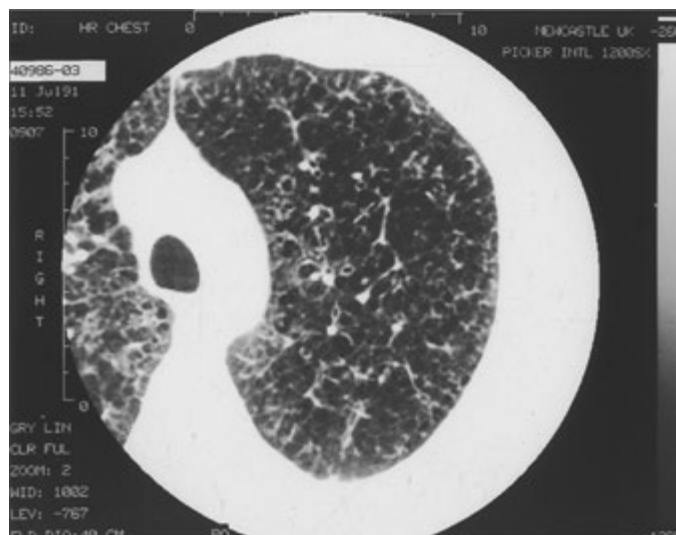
High-resolution CT of a 45-year-old smoking man with biopsy-proven Langerhans' cell histiocytosis, showing centrilobular nodules, cysts, and reticulation.
